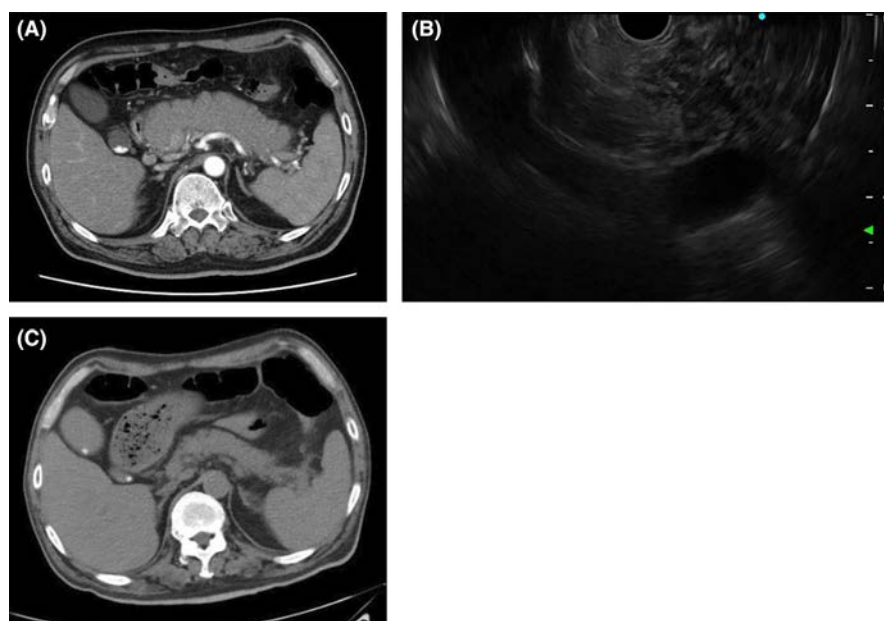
Pancreatic imaging results of the patient. (A) Abdominal enhanced CT performed at the patient's first visit shows diffuse enlargement of the whole pancreas with multiple nodular convex margin and delayed enhancement. (B) Endoscopic ultrasonography shows that the pancreatic parenchyma was diffusely hypoechoic with patchy echo enhancement ("honeycomb" appearance). (C) Abdominal CT performed after the treatment of IVIG and prednisone shows that the diffuse enlarged pancreas was partially mitigated.
